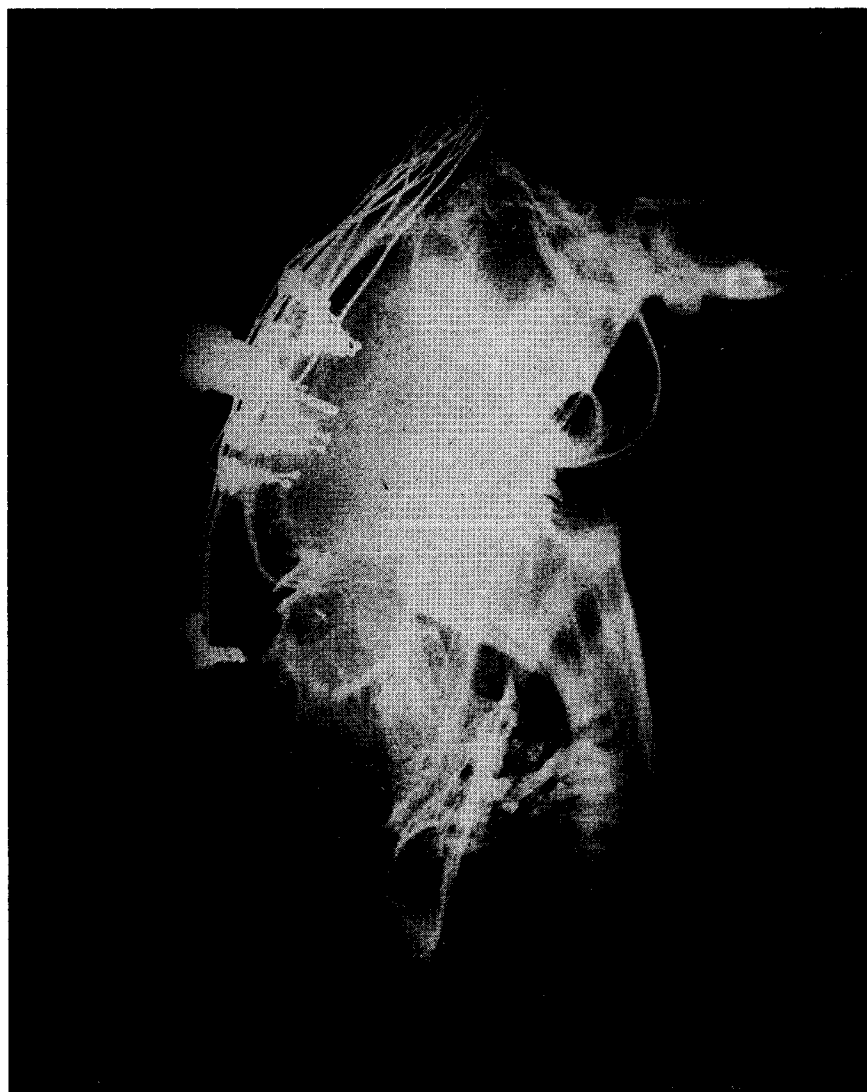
Roentgenogram showing implanted cortical electrodes and intraventricular cannula (marked by arrow).
